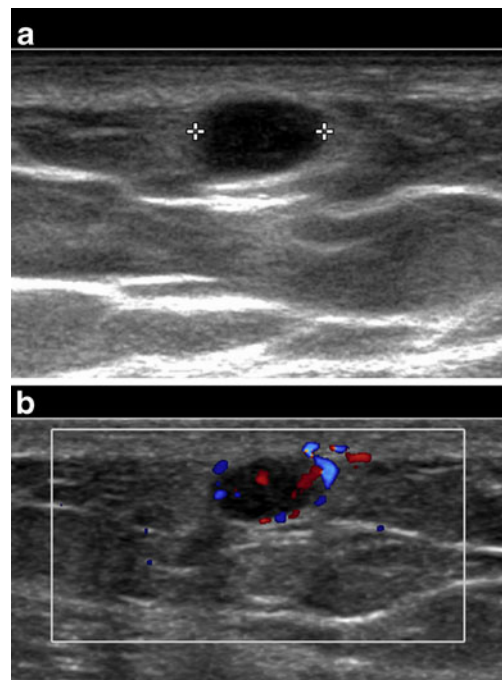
Longitudinal a B-mode and b color Doppler US images (17–5 MHz linear probe) of the lateral aspect of the right arm
